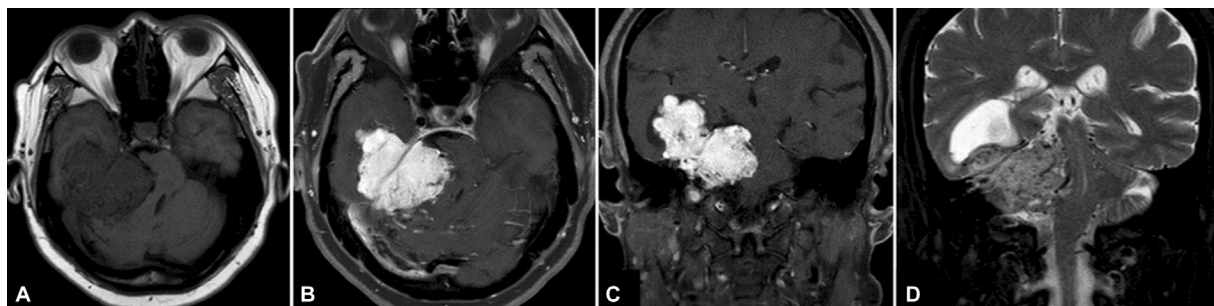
(A) Axial T1-weighted, (B) axial, and (C) coronal T1-weighted gadolinium-enhanced magnetic resonance images show intense homogeneous enhancement of the large multilobulated mass, arising from the petrotentorial region involving middle and posterior cranial fossae with irregular borders and marked brainstem compression. (D) T2-weighted fat-suppressed magnetic resonance sequence reveals multiple flow voids within the tumor.
